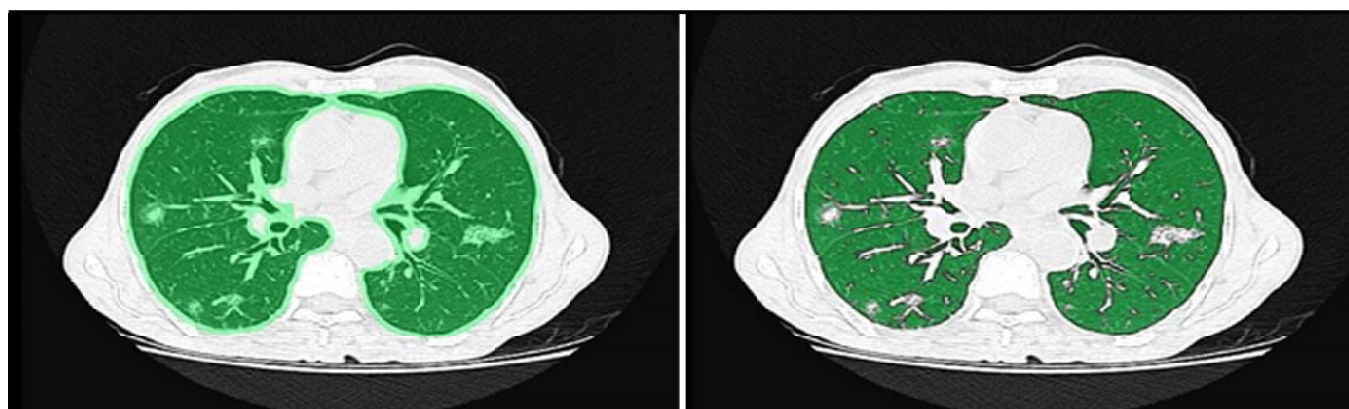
Volumetric HRCT thorax image Axial section showing whole lung volume – 3.94(L) (Includes Pathology) and normal lung volume 2.60(L) (excludes pathology).
